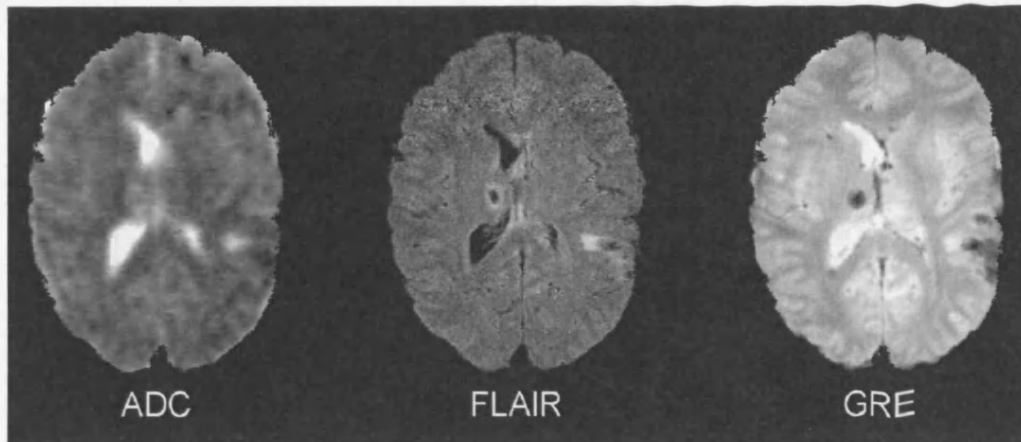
Coregistered image sets from a patient. ADC image (left), FLAIR image (middle) and GRE image (right). The left parietal contusion and right mid brain contusions show a hypointense core on all three image sequences. The hyperintensity surrounding the core regions is uniform on FLAIR and ADC images and demonstrates that, in this patient, the T2 hyperintensity is primarily due to vasogenic oedema. The hypointense rim of tissue outside this hyperintensity is seen on ADC but is absent on GRE, excluding haematoma as a cause of this hypointensity.
